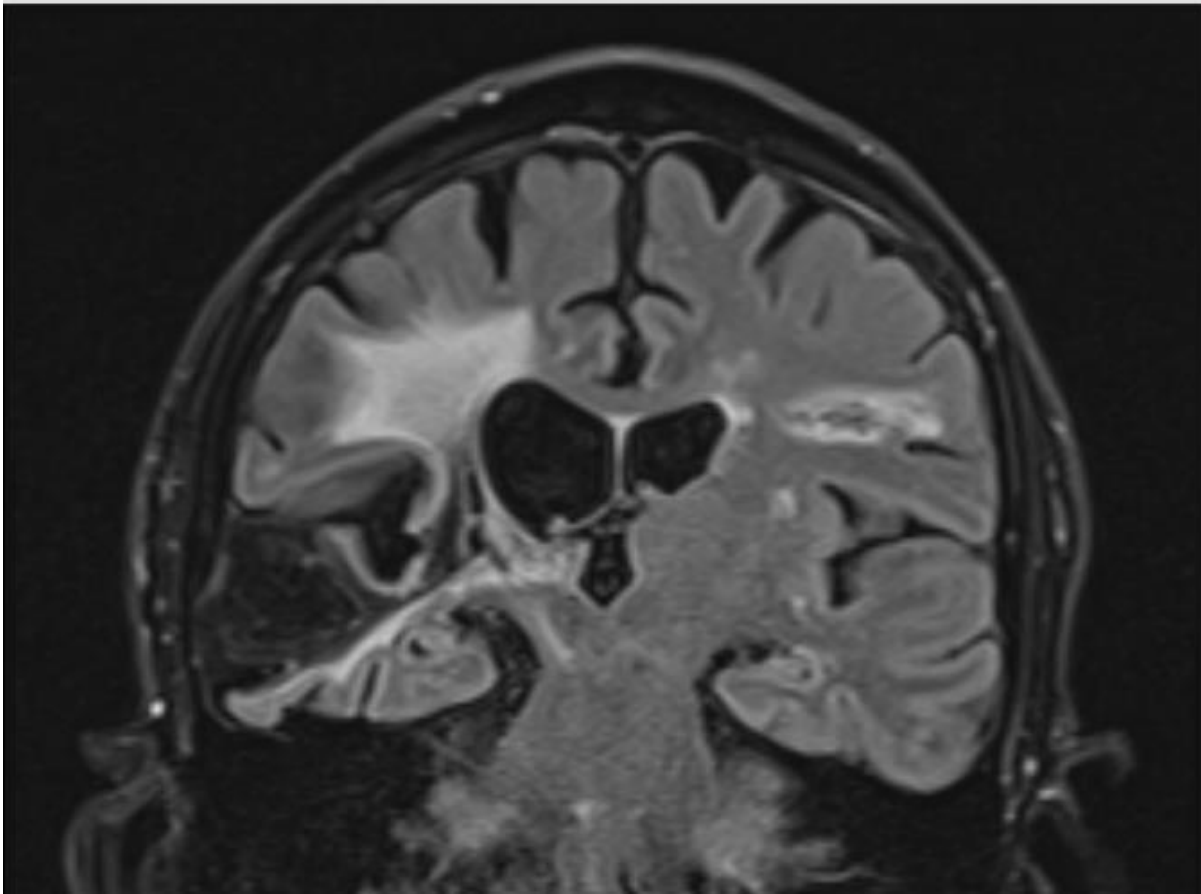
shows same MRI head in T2 coronal plane.
